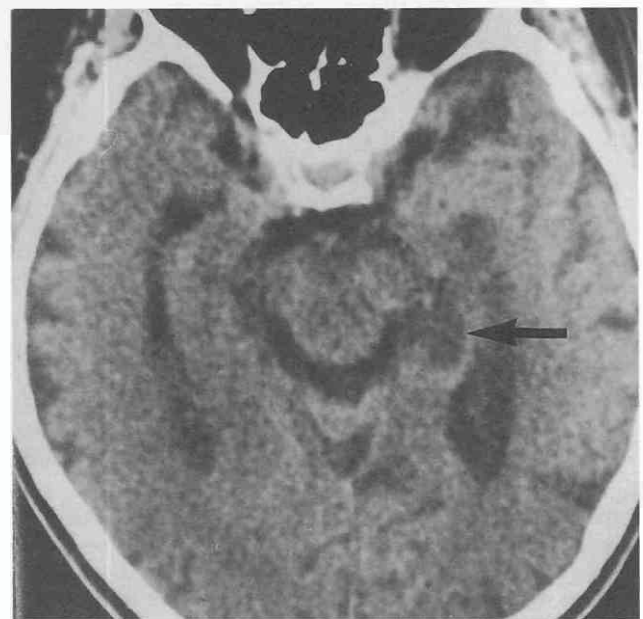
Clinical Alzheimer's disease. Reverse-angle CT scan (angled parallel to the hippocampus) demonstrates an area of decreased density in the medial aspect of the temporal lobe (arrow). The density of this area approaches that of cerebrospinal fluid. This corresponds to dilatation of the perihippocampal fissures and is an accurate indicator of hippocampal atrophy. (From Holodny AI, George AE, Golomb J, et al: The perihippocampal fissures: Normal anatomy and disease states. Radiographics 18: 653-665, 1998.)
